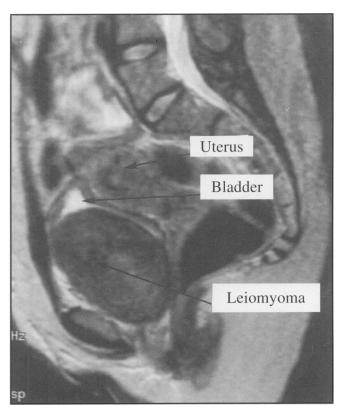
MRI Scan: Sagittal (FSE/TR4000/TE85) – The mass has an inhomogenous signal with a central region of diffuse high signal. The tumour has a well defined margin and is separate from the vagina and uterus. Small low signal foci can be seen.
